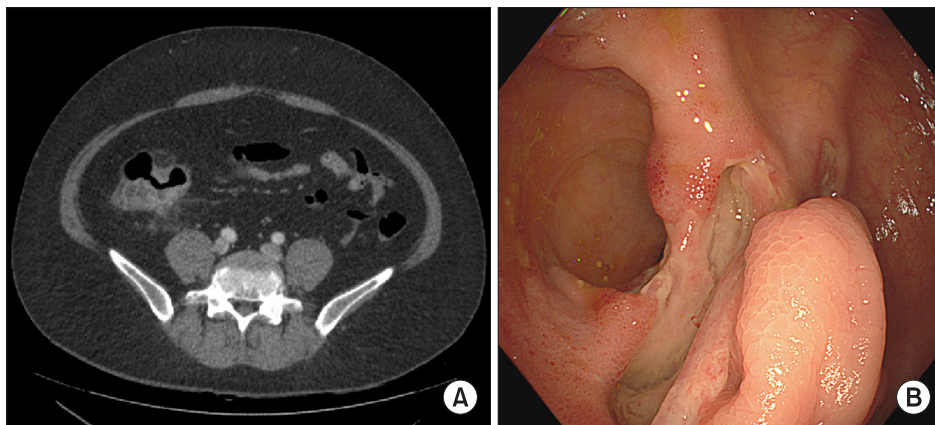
(A) Computed tomography finding showed layered enhancing wall thickening with perilesional fat infiltration and ulceration in terminal ileum. (B) Colonoscopic finding revealed large well defined deep oval ulcers in ileocecal valve.
